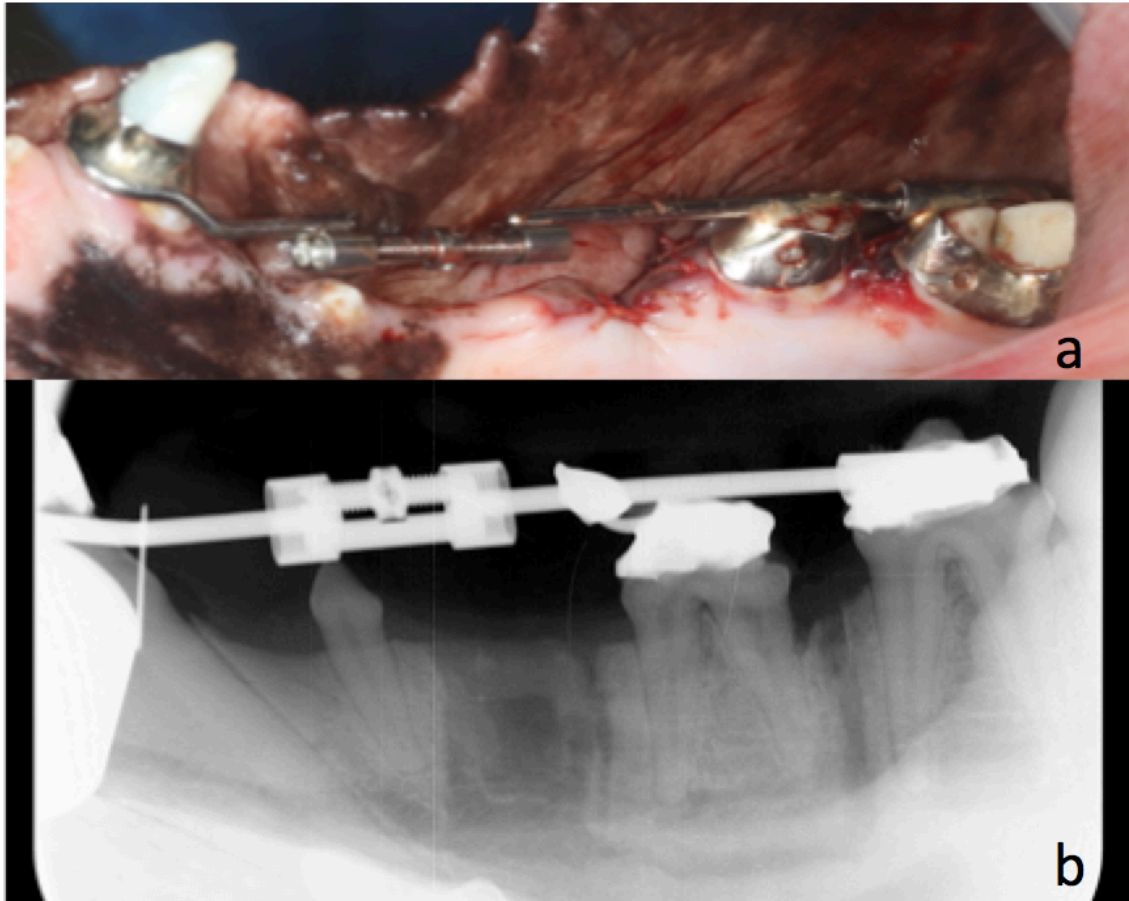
Distractor device. a) post surgical cementation lingual view b) post surgical cementation radiographic view
